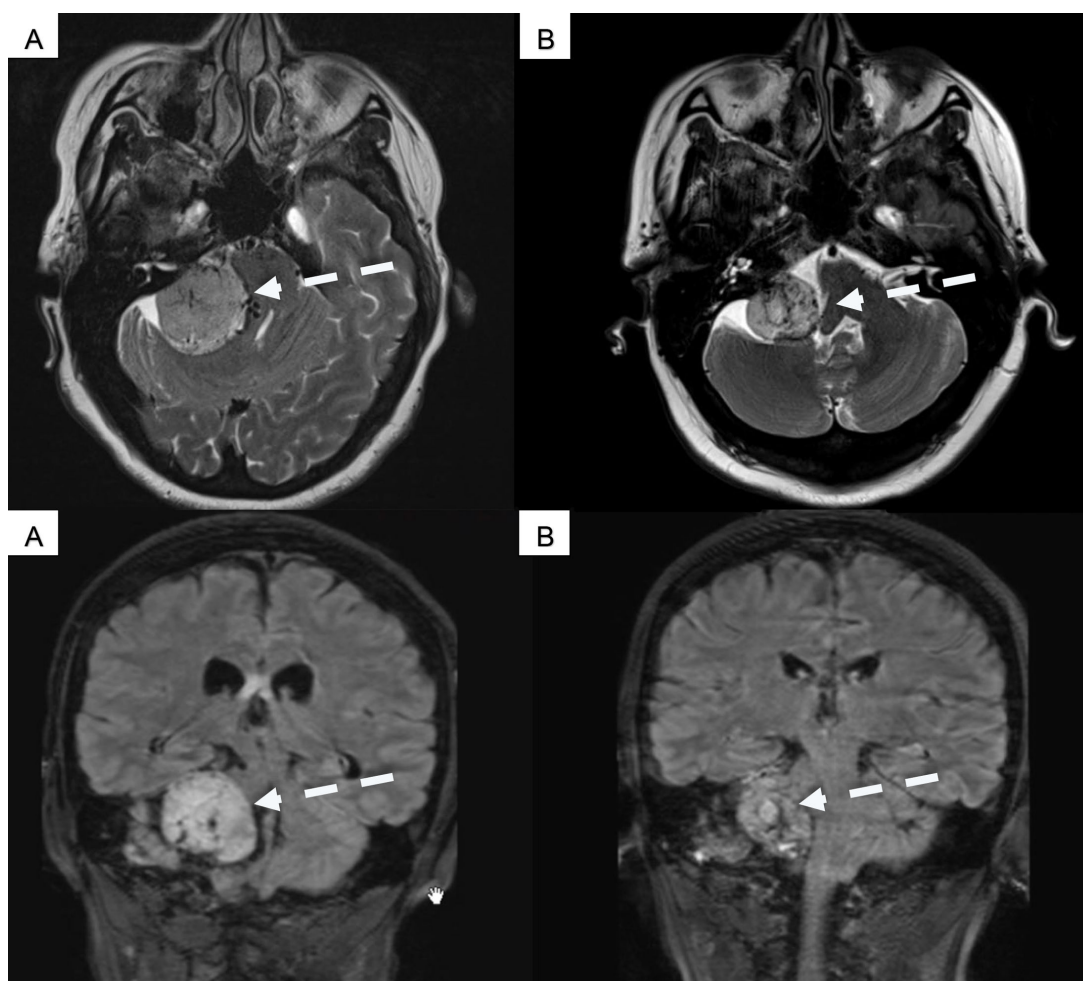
Upper pre-embolization (A) and post-embolization (B) axial brain MR T2-weighted sequences and lower pre-embolization (A) and post-embolization (B) coronal MR T1 sequences of our patient showing around a reduction of the size lesion of approximately 25–30% 1 month after endovascular embolization.
